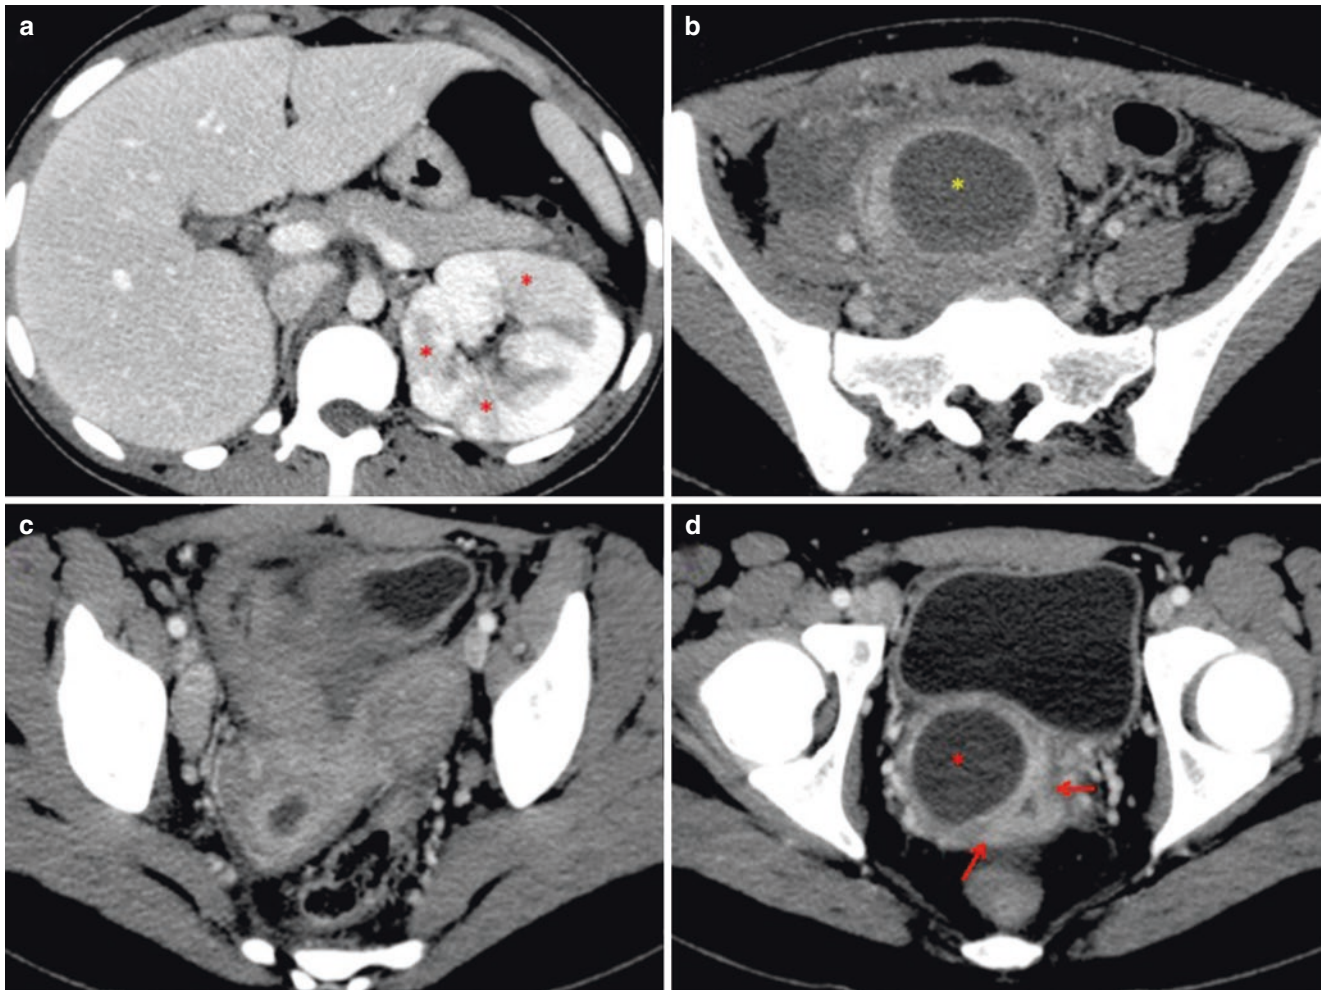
Axial CT images of the complete abdomen with intravenous contrast. (a) Agenesis of the right kidney, with the left presenting vicarious aspects and signs of pyelonephritis, characterized by the sparse hypodense cuneiform areas in the parenchyma (*red asterisks*). (b) The *yellow asterisk* corresponds to image (a) of Fig. 32 (mesogastric lesion). (c) Clear bifid and divergence between the uterine horns (*yellow*
